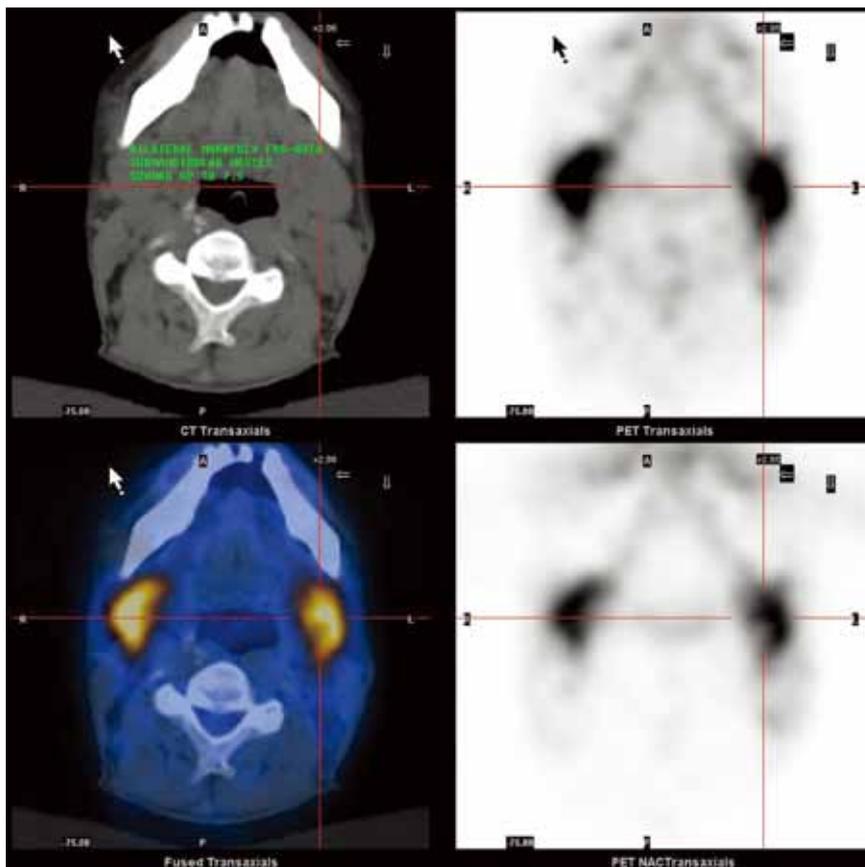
Positron emission tomography-computed tomography shows markedly hypermetabolic enlarged bilateral submandibular masses with a maximum standardised uptake value up to 7.5. Subsequent left submandibular biopsy revealed immunoglobulin G4-related systemic disease.
